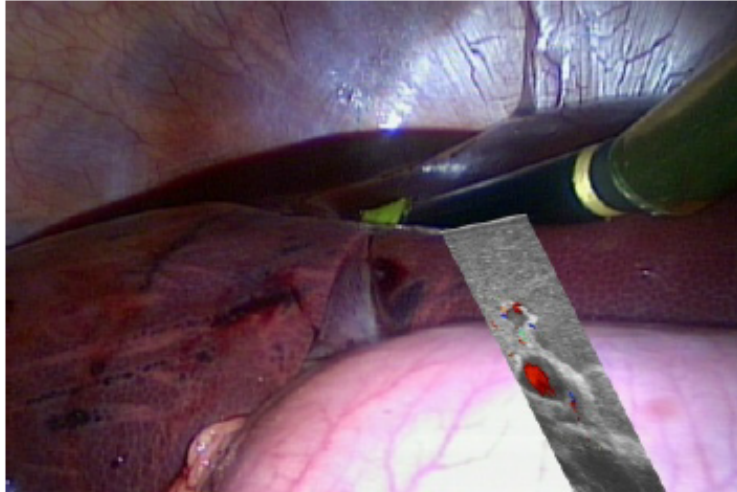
Ultrasound image overlay on the endoscope optical image (Image from [Ogu+14])
